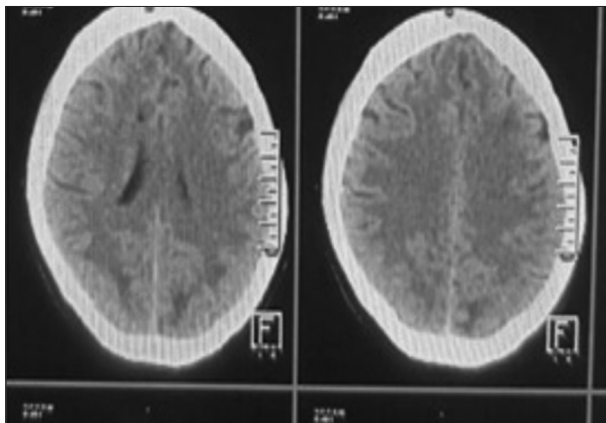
Follow-up computed tomography brain showing reduction in the number and size of tuberculomas and near complete resolution of edema
